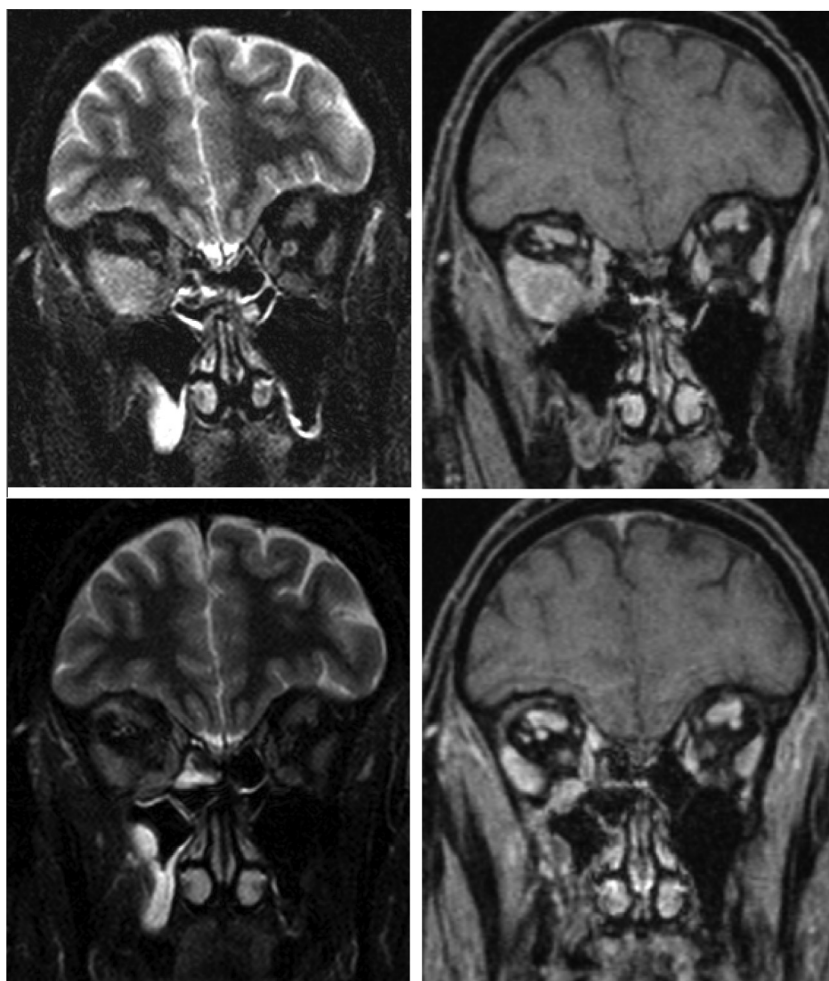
Findings on MRI of orbits on presentation (top row) and 6 months later, after having received steroid treatment (bottom row), on coronal fat saturated T2-weighted (A, C) and gadolinium-enhanced T1-weighted images (B, D), showing enlargement of the right lateral rectus muscle with homogenous attenuation and enhancement with improvement at 6 months. Mucosal thickening of adjacent air sinuses is also appreciated.
